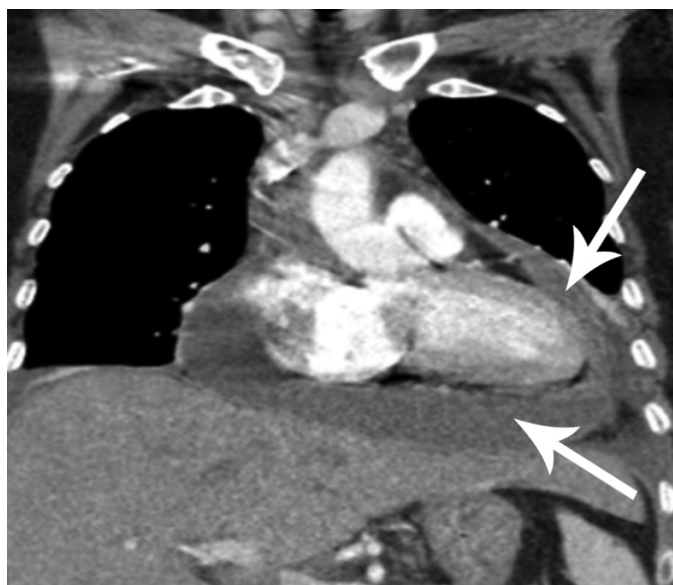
Thoracic computed tomography image in the sagittal plane showing pericardial effusion (arrows)
